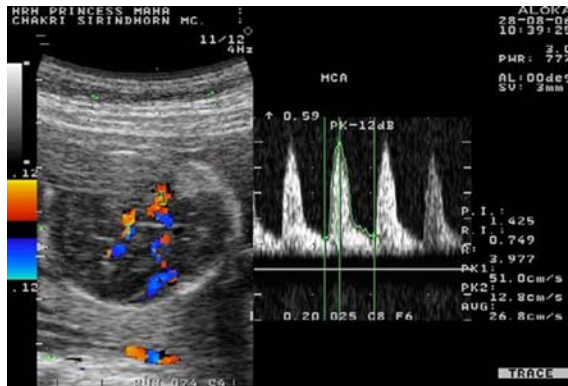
Color Doppler ultrasound image showing the middle cerebral artery peak systolic velocity (MCA-PSV) of the second case.
